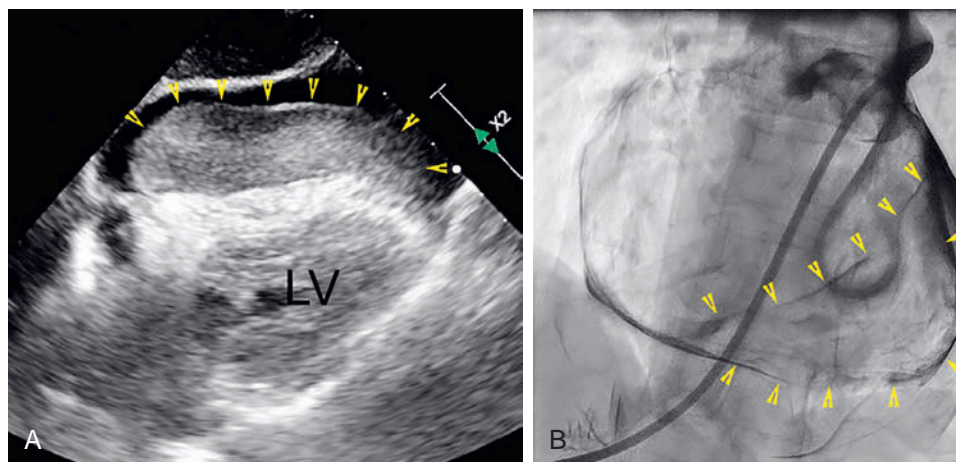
Intrapericardial Thrombus. Transthoracic echocardiography (A) and contrast pericardiography (B) in a patient who developed cardiac perforation and hemopericardium following catheter ablation of atrial fibrillation. Reversal of heparin effects with protamine and pericardiocentesis was performed via the subxiphoid pericardial access approach. A pigtail catheter pericardial drain was inserted in the pericardial space, and pericardiography was performed by contrast injection through the drain. Note the large intrapericardial thrombus (arrowheads) overlying the left ventricle (LV).
